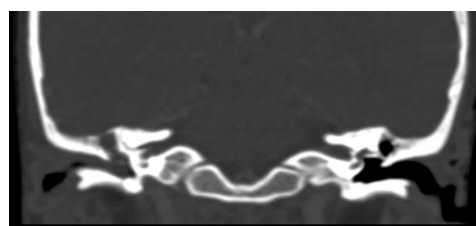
Coronal HRCT image of temporal bone showing soft tissue opacification at the left external auditory canal extending into tympanic cavity with erosion of inferior wall of external auditory canal, scutum and left incus.
